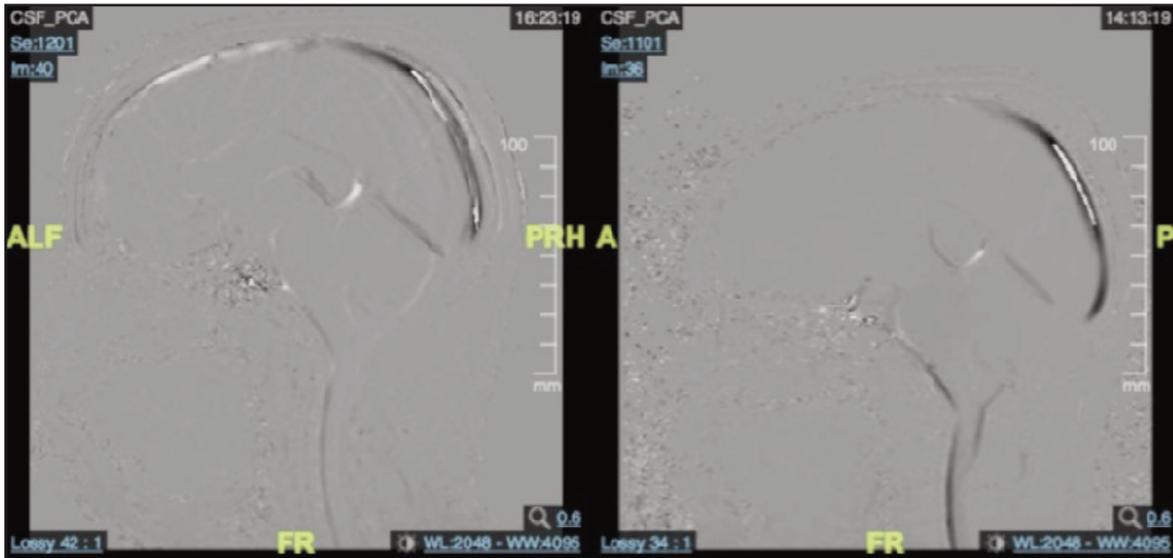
MRI CINE showed pre (Left) and postoperative (Right) CSF flow at posterior foramen magnum.
